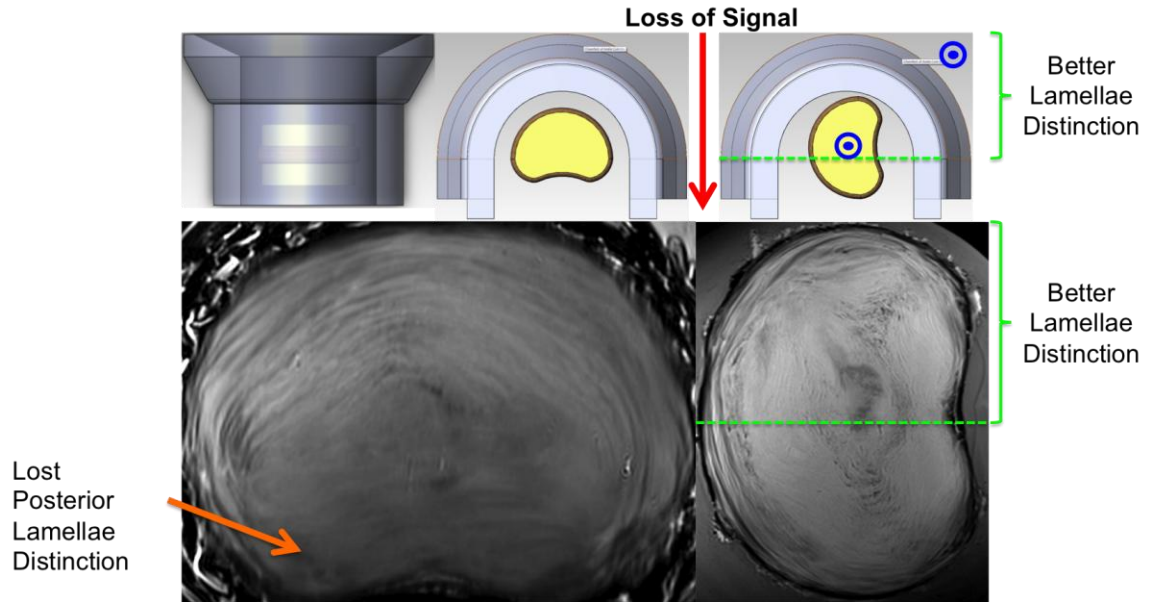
Effect of signal to noise ratio (SNR) on disc positioning within the MRI. Red arrow indicates the direction of lost signal within the RF coil. Clinically relevant anatomic orientation (Left Side) results in decreased posterior AF lamellar distinction (Orange Arrow). Lateral positioning of the disc (Right Side) enables the spine axis and B_0 (Blue Circle: dot indicates spine axis and B_0 direction) to be parallel, decreasing banding artifacts within the disc during image acquisition.
